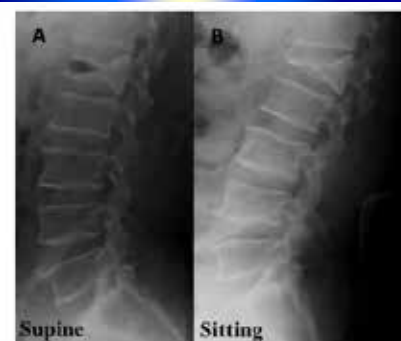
(A) Lateral X-ray taken in the supine position before balloon kyphoplasty (BKP). The intravertebral cleft can be observed. (B) Lateral X-ray taken in the sitting position before BKP. The intravertebral cleft has disappeared.
